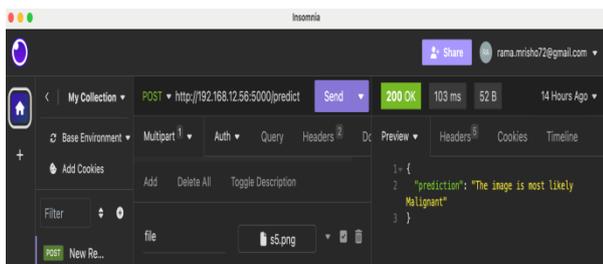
shows a result of an API end point after submit an MRI image file.
